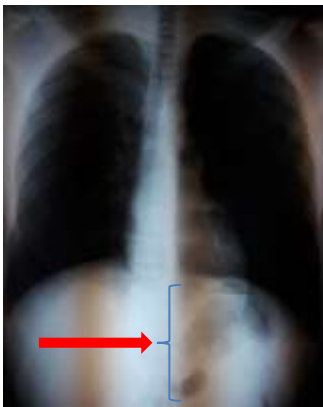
A plain chest radiograph in the erect position with normal chest findings and dilated loops of small bowel in the left upper quadrant (shown with arrow) which does not demonstrate a pneumo-peritoneum.
